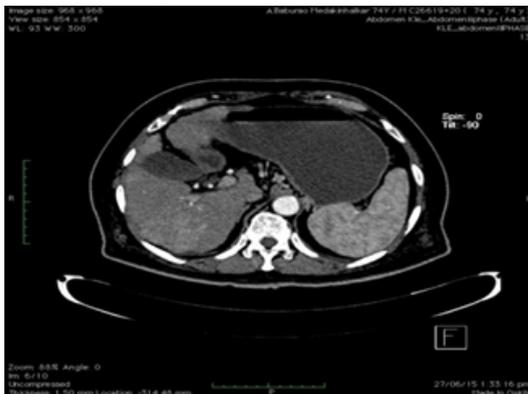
Shows the CT-abdomen of the patient showing ill defined enhancing lesions in the head of the pancreas with metastases in V,VI lobes of the liver.
